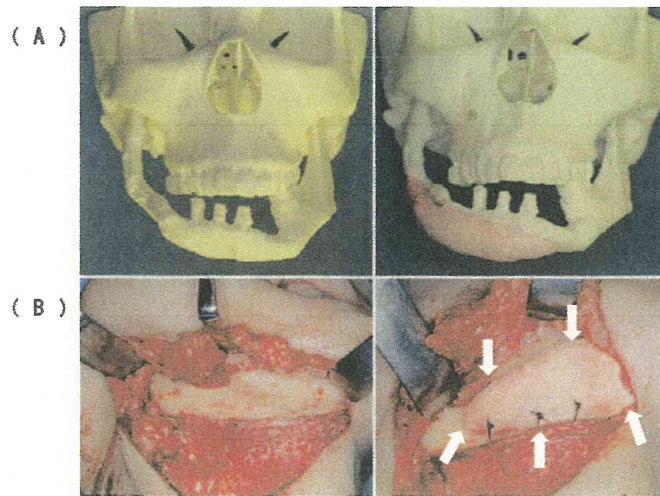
カスタムメイド人工骨 (CT bone)
